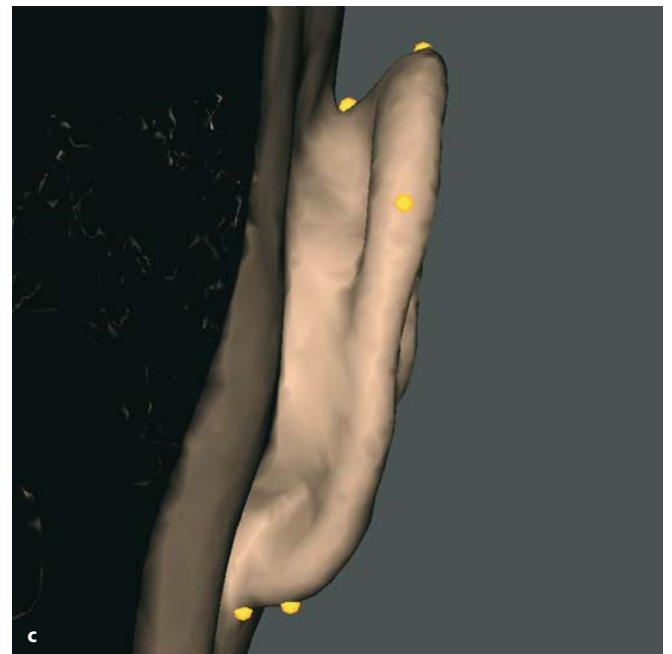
a–c. Ear related 3-D cephalometric soft tissue landmarks. Right profile (a), frontal (b), dorsal (c) view (3-D CT, patient K.C.)
